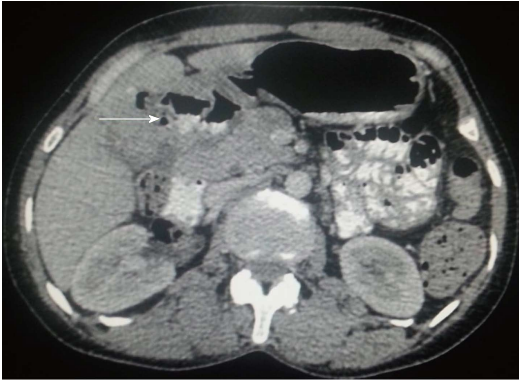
Aggressive gallbladder cancer and entero-biliary fistula. A: Axial contrast-enhanced computed tomography (CECT) abdominal section shows predominantly hypodense mass lesion replacing gall bladder fossa with presence of air (arrow) raising suspicion of fistula formation. Adjacent hepatic segments are also infiltrated by the mass; B and C: Axial and Coronal CECT abdominal sections clearly reveal the fistulous communication with D2 segment of duodenum (arrow); D: Coronal CECT abdominal section also show coexisting cholecysto-colonic fistula with hepatic flexure of colon (arrow).
